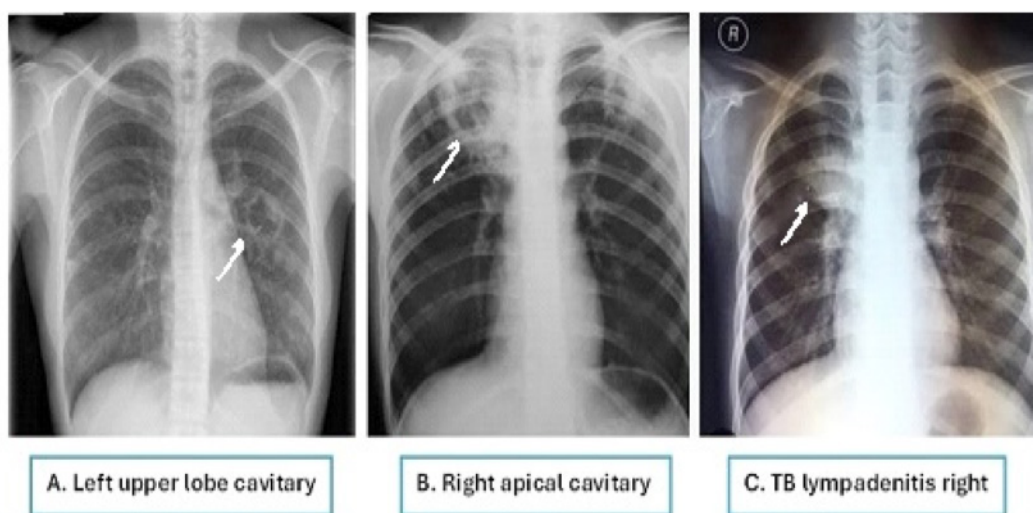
Chest X-ray findings in tuberculosis.
